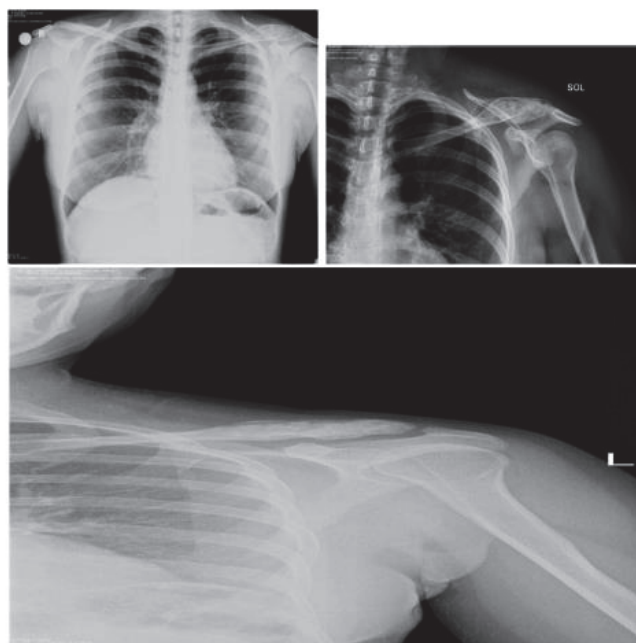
ABC located in the left clavicle in a 40-year-old female patient. A) direct radiograph of a septal cystic lesion extending to the diaphysis in the distal clavicle on direct X-ray b) Post-operative direct X-ray after curettage + allograft (tricalcium phosphate) c) Post-operative 4th month X-ray
